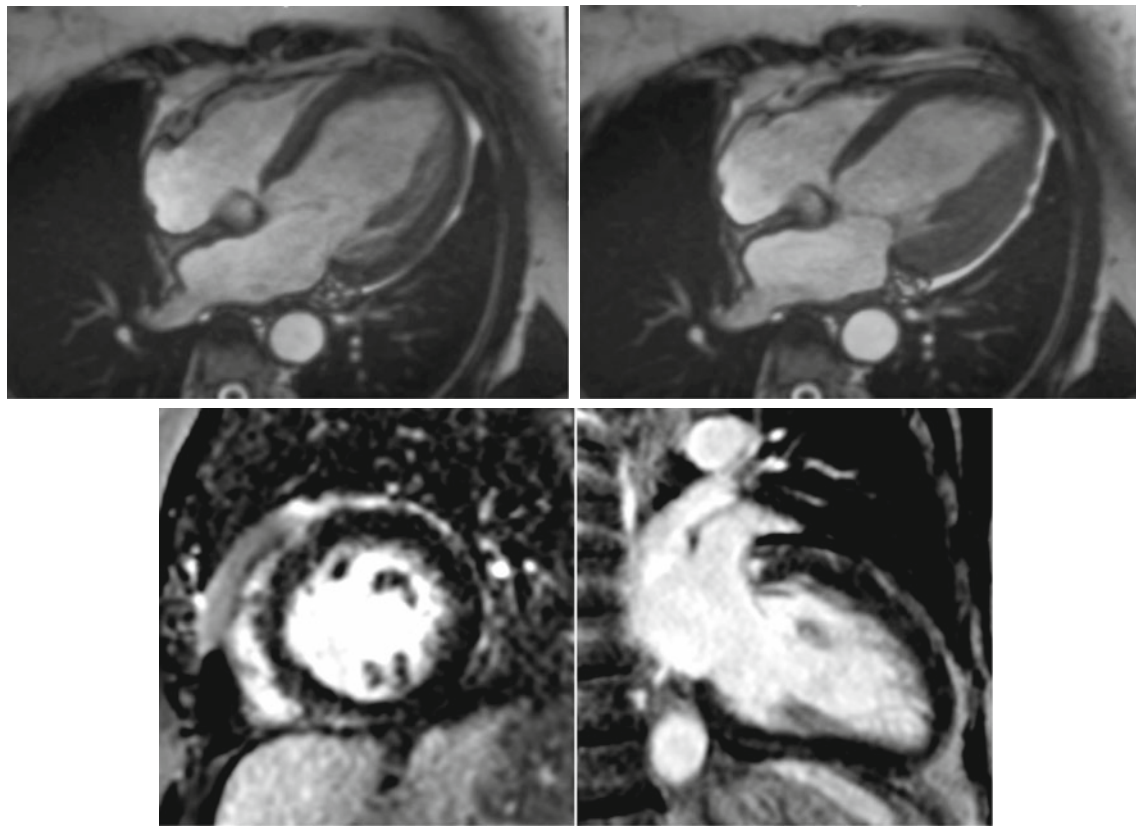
Cardiac MRI: Top: Four-chamber balanced Steady-State Free Precession sequence: LV dilatation with moderate to severe global hypokinesia and septal dyskinesia. End diastolic frame (left) and end systolic frame (right) Bottom: Short Axis and two-chamber
